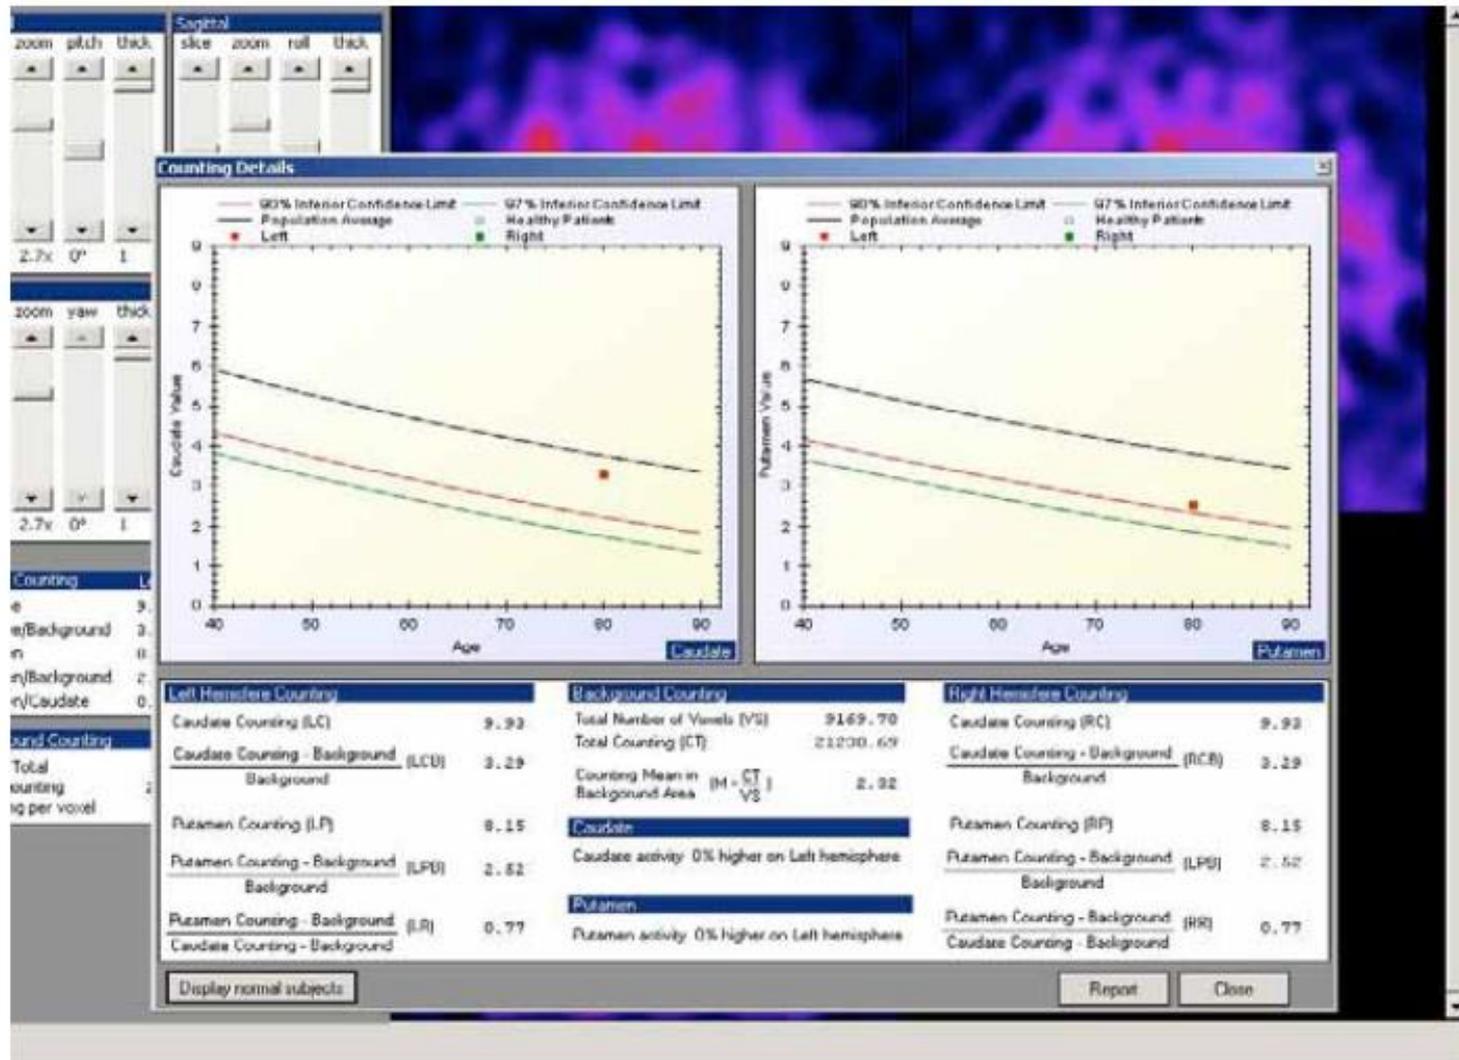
Example of the SPECT images evaluation by using the Basal Ganglia software version 2.
